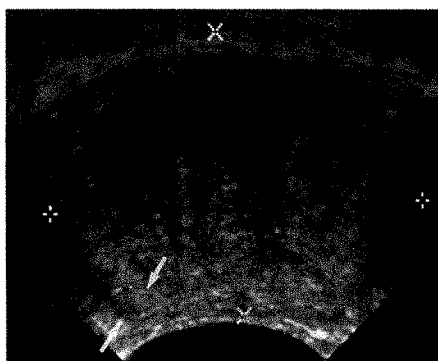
Benign prostatic hypertrophy. Transverse image shows markedly enlarged central portion of gland (cursors) with compression of peripheral zone (arrows). Hypertrophied tissue is heterogeneous, hypoechoic, and strongly attenuates ultrasound beam.
